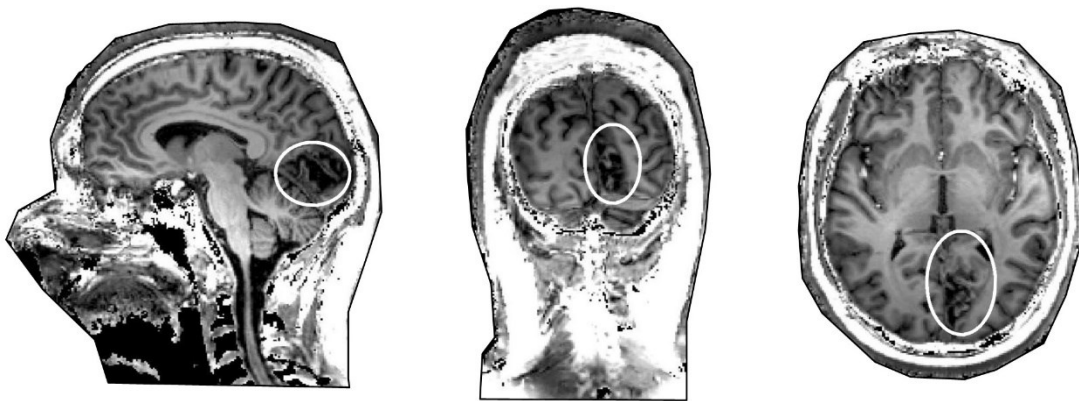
Structural magnetic resonance images in sagittal, coronal and axial view indicating the location of the patient's occipital lesion. The white circle shows the location of lesion.
